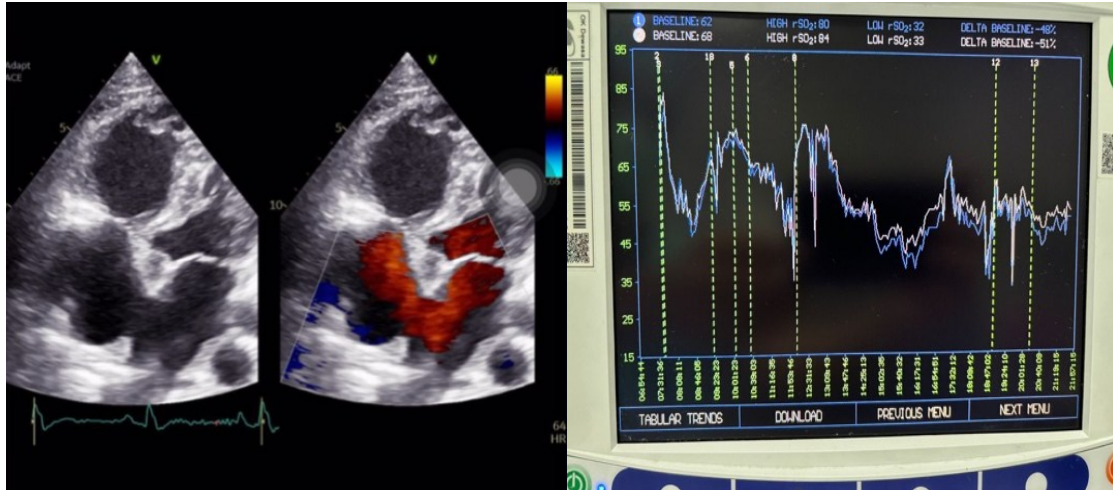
Echocardiographic image of the patient and NIRS monitoring
